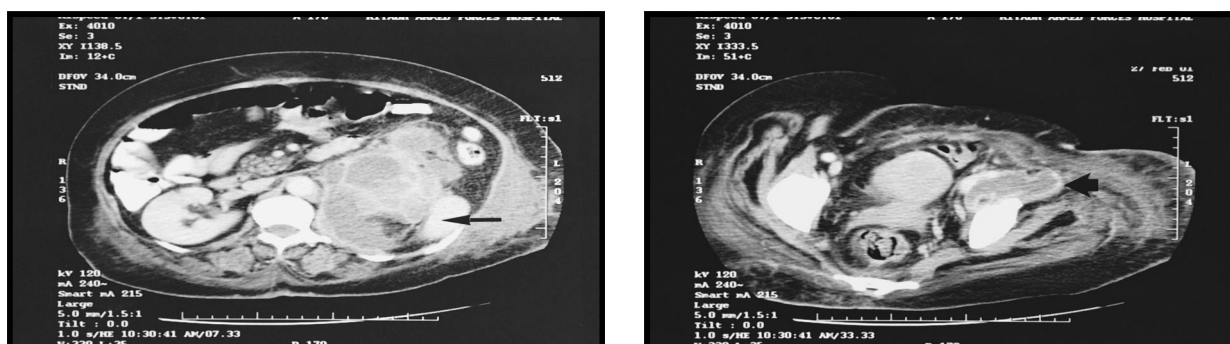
Computed tomography scan showing (a) a huge multiloculated left retroperitoneal abscess obscuring the atrophied kidney. Solid tissue on the lateral aspect (black arrow) is the spleen and (b) demonstrates extension of the iliopsoas abscess (black arrow) into the anterior compartment of the left thigh.
